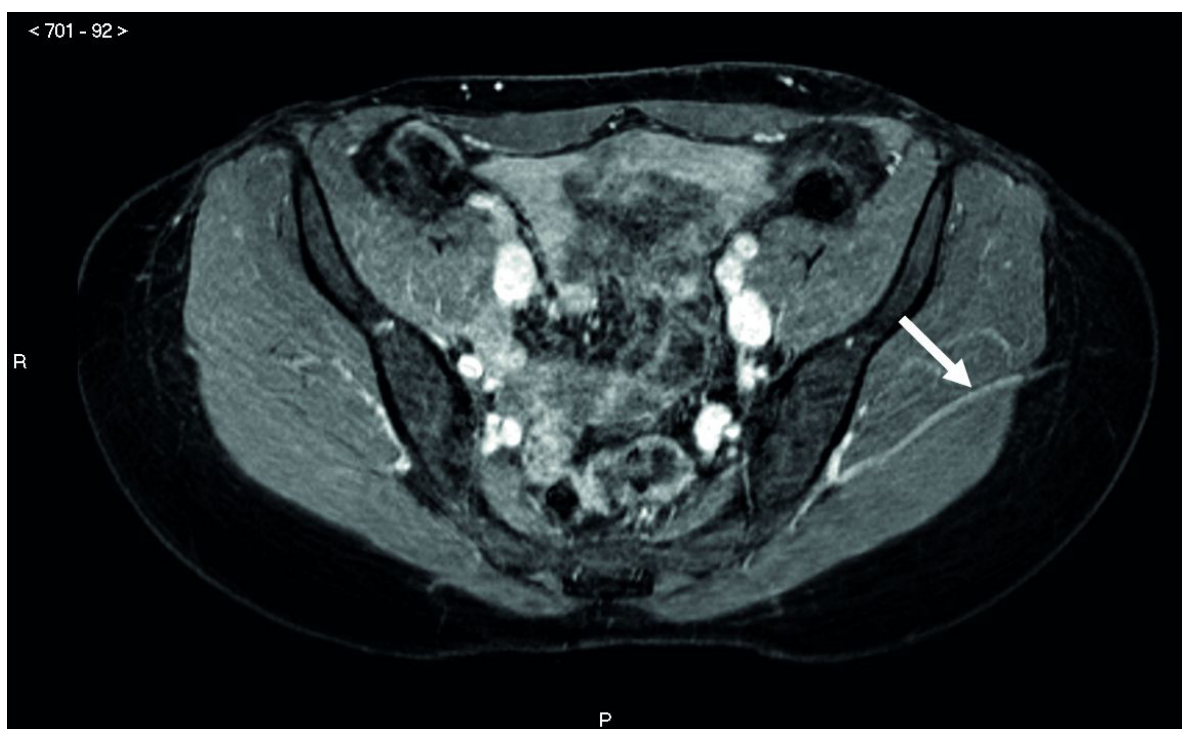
Transverse, three-dimensional T1-weighted FFE sequence ('THRIVE') on MRA. The arrow shows the comitant perforator artery running between gluteus maximus and medius muscle.
